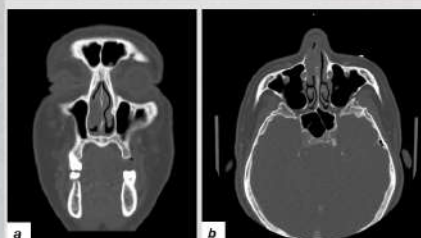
a-b: Preoperative Computed Tomography (CT) scan of paranasal sinuses with contrast.
